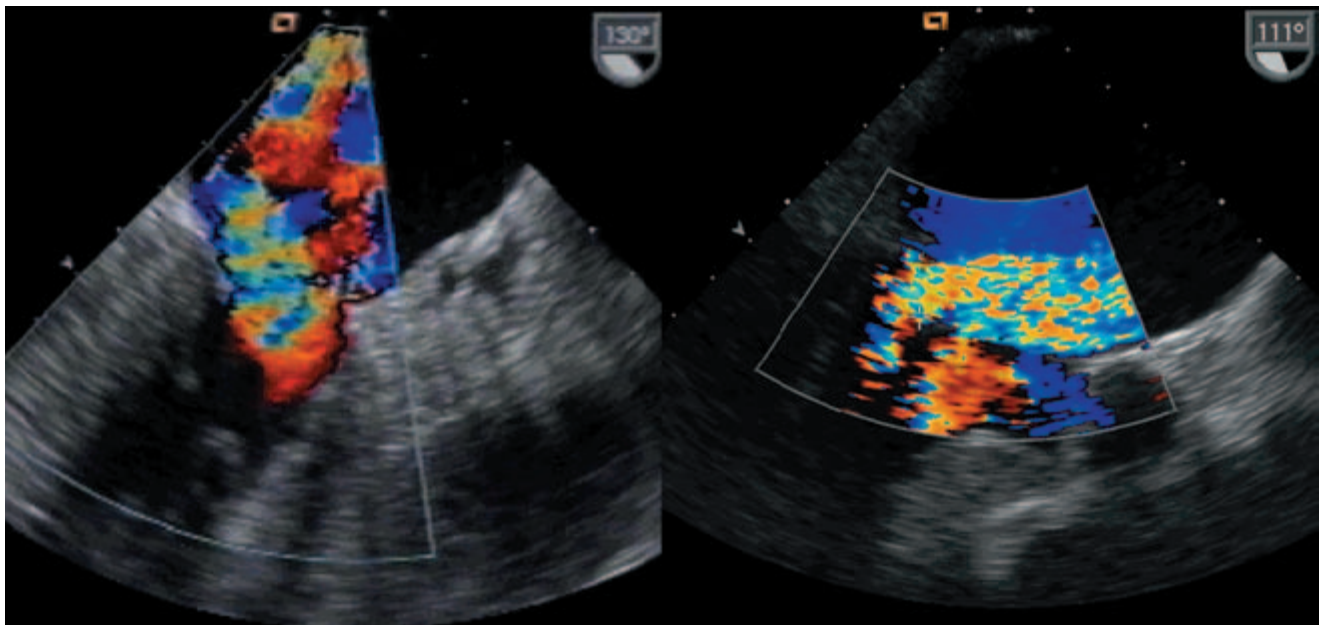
Prolapse of the mitral leaflets. Transoesophageal view. Left, prolapse of the posterior leaflet (P2); right, prolapse of the anterior leaflet (A2). (Courtesy of Dr E. Brochet.)
